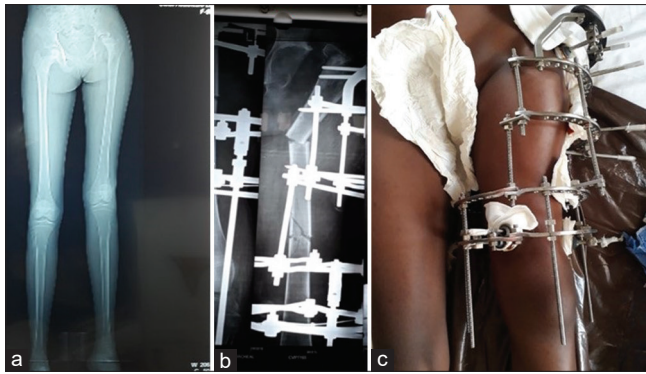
Ilizarov frame used for pelvic support osteotomy and lengthening. (a) Scanogram showing LLD and hip pathology. (b) X-rays showing frame assembly following pelvic support osteotomy and corticotomy for distraction. (c) Clinical image showing frame assembly. Photographs provided courtesy of Dr. Emeka Izuagba and used with permission copyright 2020, National Orthopaedic Hospital, Igbobi, Lagos, Nigeria
